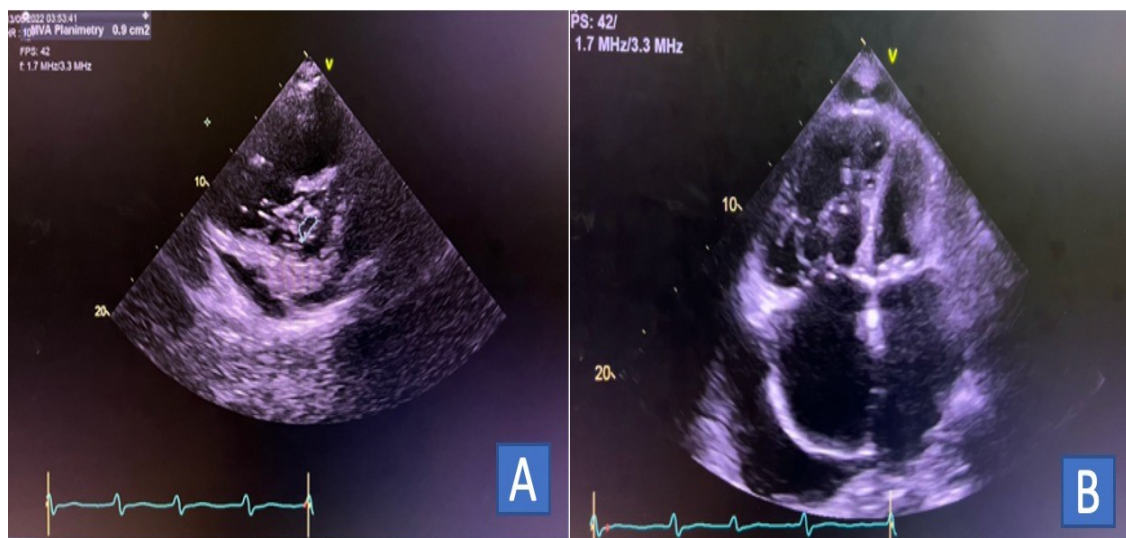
A. Parasternal short axis view showing mitral valve area (MVA) $<0.9 \text{ cm}^2$. B. Chamber view showing severe dilatation right sided cardiac chamber, bowing interatrial septum into the LV due to elevated right atrial pressure.
